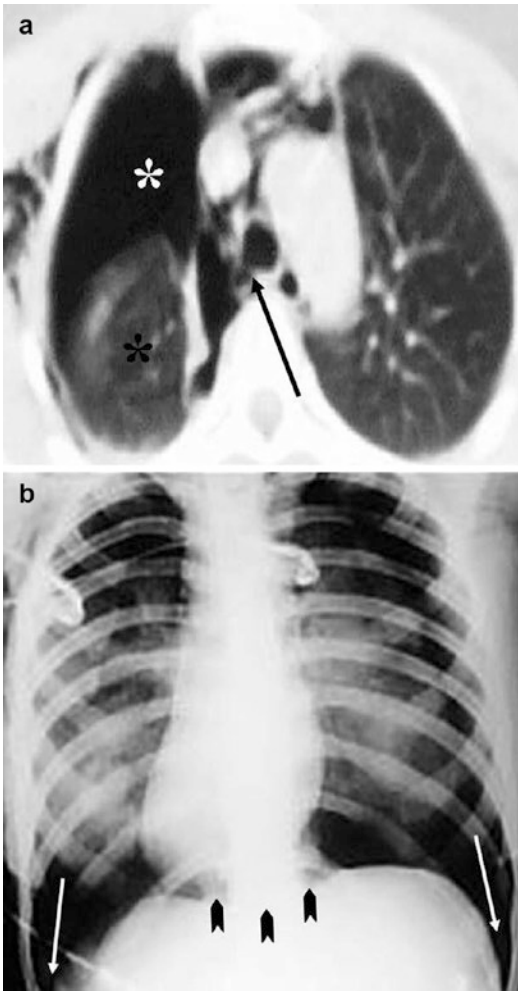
Blunt bronchial injury (a) CT scan shows right-sided subcutaneous emphysema, pneumothorax (white asterisks), and pneumomediastinum. The right lung, which is partially collapsed, is detached from the main bronchus (arrow) and drops posteriorly (black asterisk) in the right hemithorax—the “fallen lung” sign. (b) Supine chest X-ray shows the “deep costophrenic sulcus” sign (arrows) and the “continuous diaphragm sign” (arrowheads) (Reproduced with permission from Elsevier)
